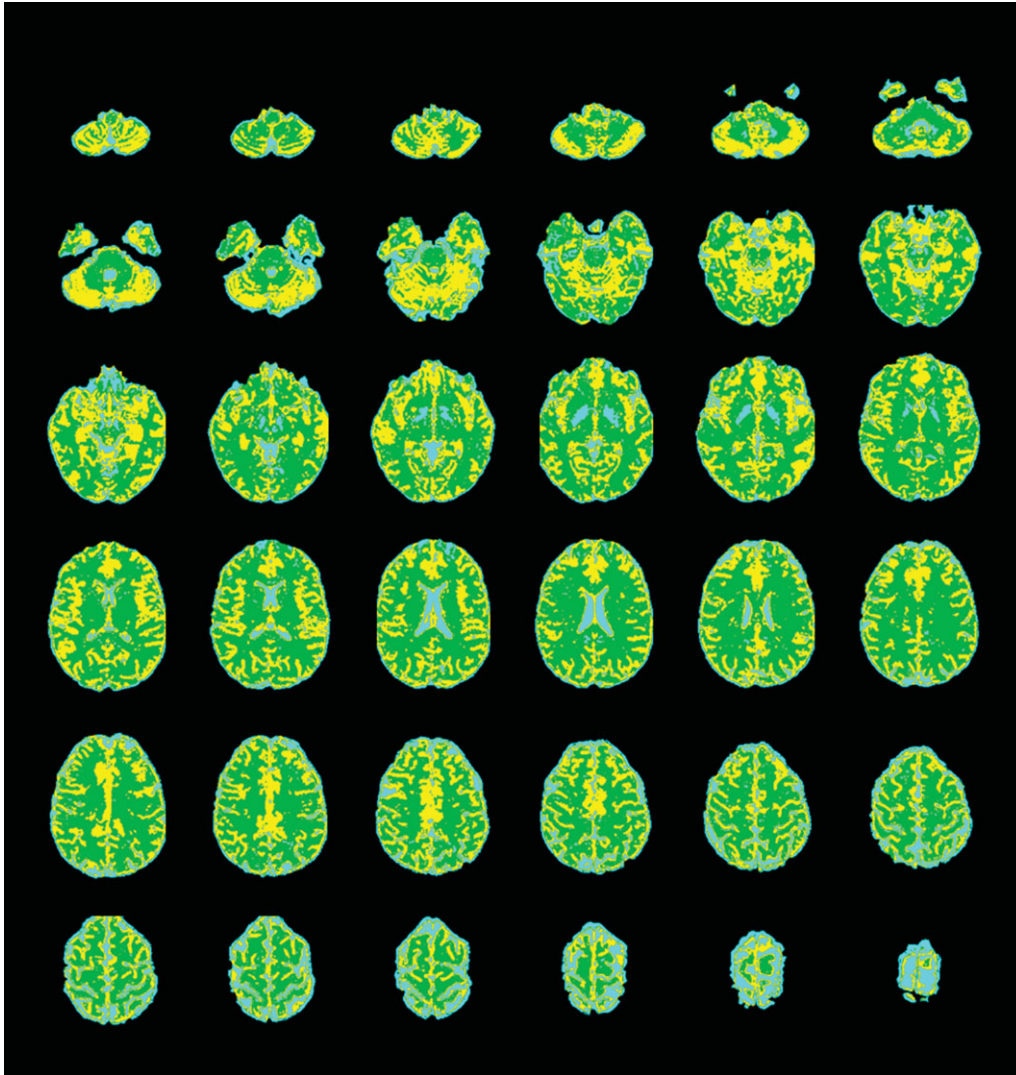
b_0 (T2-weighted contrast) image of a control subject (same subject as in Fig. 5) was segmented using FAST segmentation algorithm in FSL (32). The first compartment (white matter) is shown in green, the second (gray matter) in yellow, the third (CSF) in blue. [Color figure can be viewed in the online issue, which is available at wileyonlinelibrary.com.]
